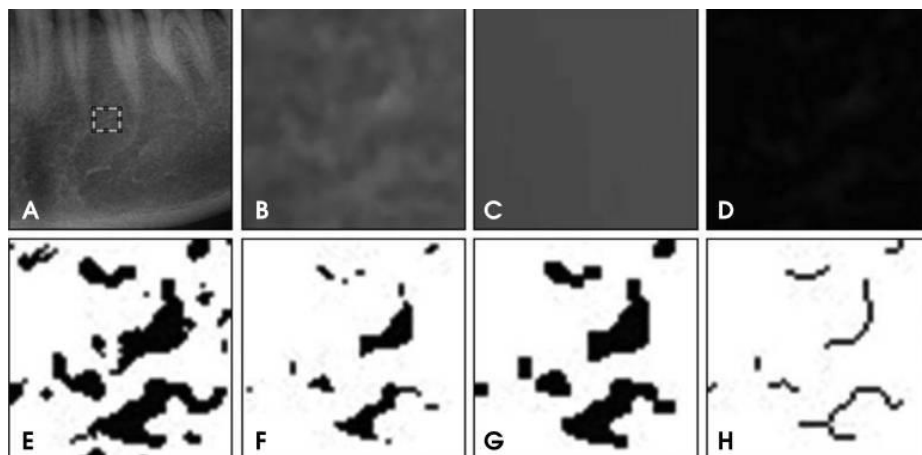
Texture analysis. A. ROI on a panoramic radiograph. B. Raw image before processing. C. Gaussian blurred image, D. Subtraction image. E. Binary image. F. Eroded image. G. Dilated image. H. Skeletonized image. From: Koh et al., 2012.
